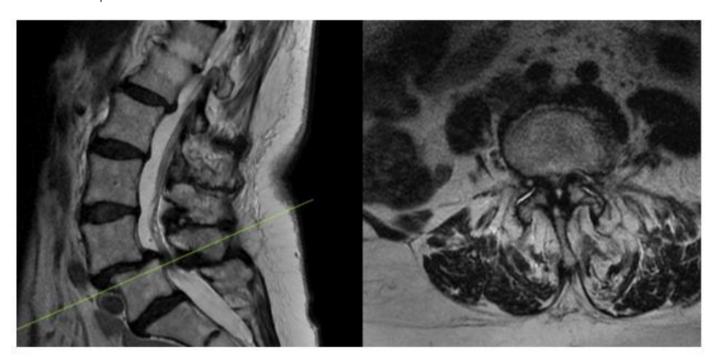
Preoperative MRI showing L4-5 Grade 1 Spondylolisthesis with associated stenosis
